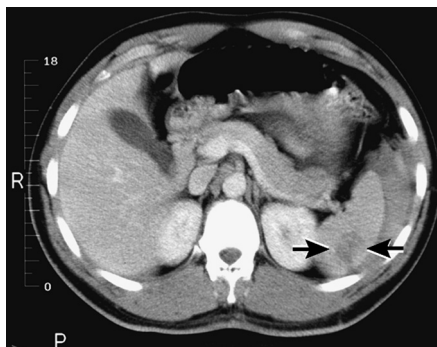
Splenic laceration. This computed tomography (CT) scan performed on a patient after a motor vehicle accident shows a dark area near the posterior aspect of the spleen (arrows), which is the laceration. Note also the blood surrounding the spleen. (From Mettler F. *Essentials of radiology*. 2nd ed. Philadelphia: Saunders, 2004, Fig. 6-60.)
